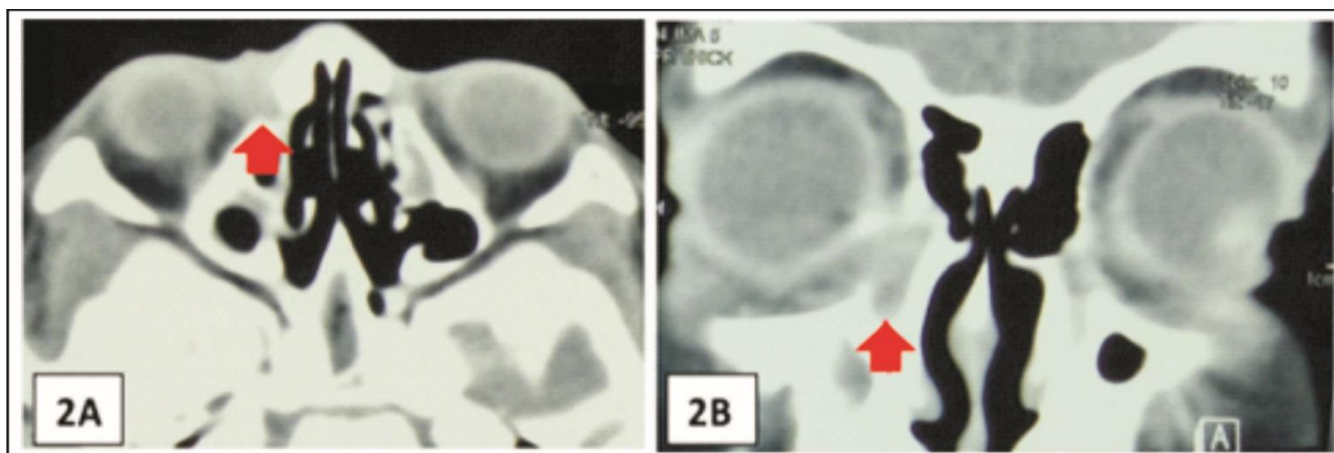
(2A): Preoperative computed tomography scan axial section showed right isodense mass on lacrimal sac area (red arrow); (2B) coronal section.
